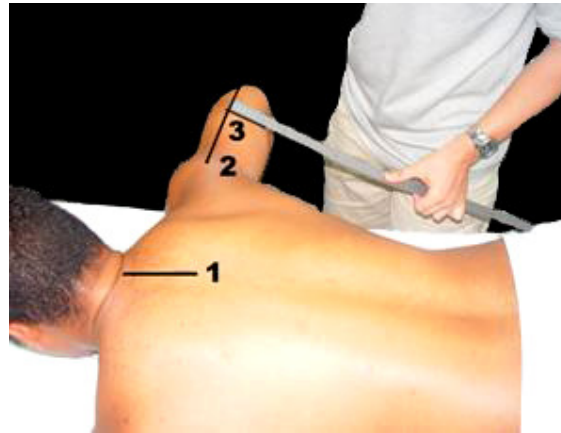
Determination of ultrasound measurement position.
